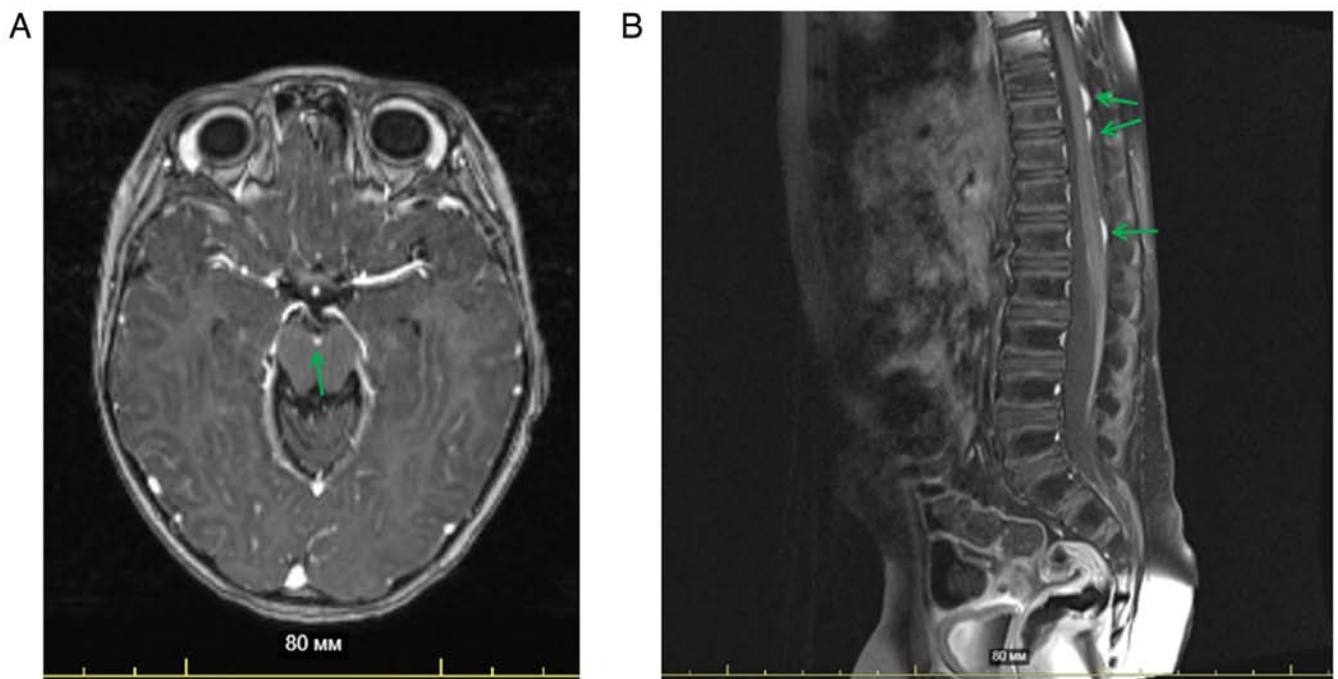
Central nervous system MRI of the patient at 14 months after discontinuation of the metronomic chemotherapy. (A) Brain MRI (Ax T1 MPR + C) indicating contrast enhancement in the region of the interpeduncular cistern (green arrow; scale bar, 80 mm). (B) Spinal cord MRI (Sag T1 TSE + C) revealing multiple metastatic lesions of the meninges of the spinal cord at the level of Th6, Th11-12, Th12-L1 with intensive contrast enhancement (green arrows; scale bar, 80 mm).
